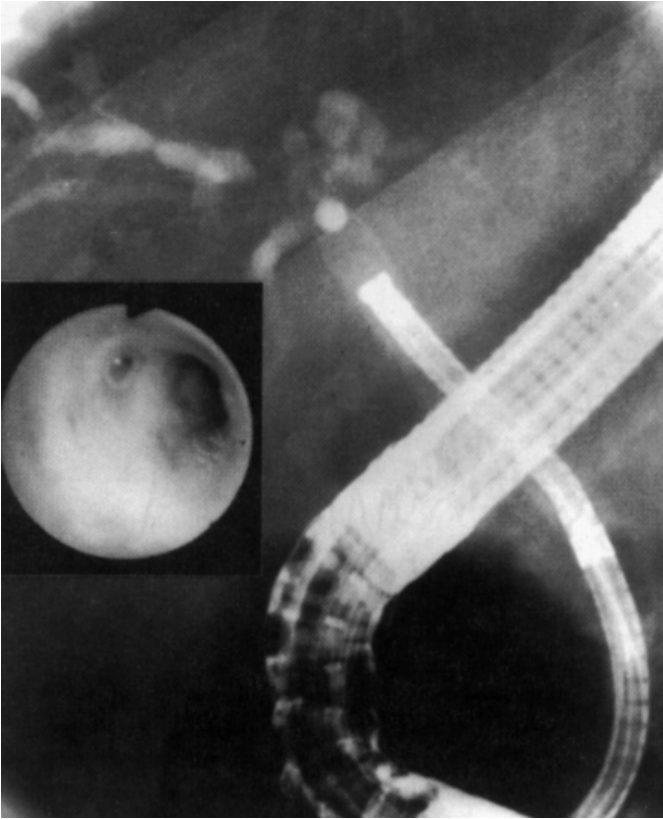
Radiography showing the 'baby' choledochoscope passed up the bile duct through the 'mother' instrument.
